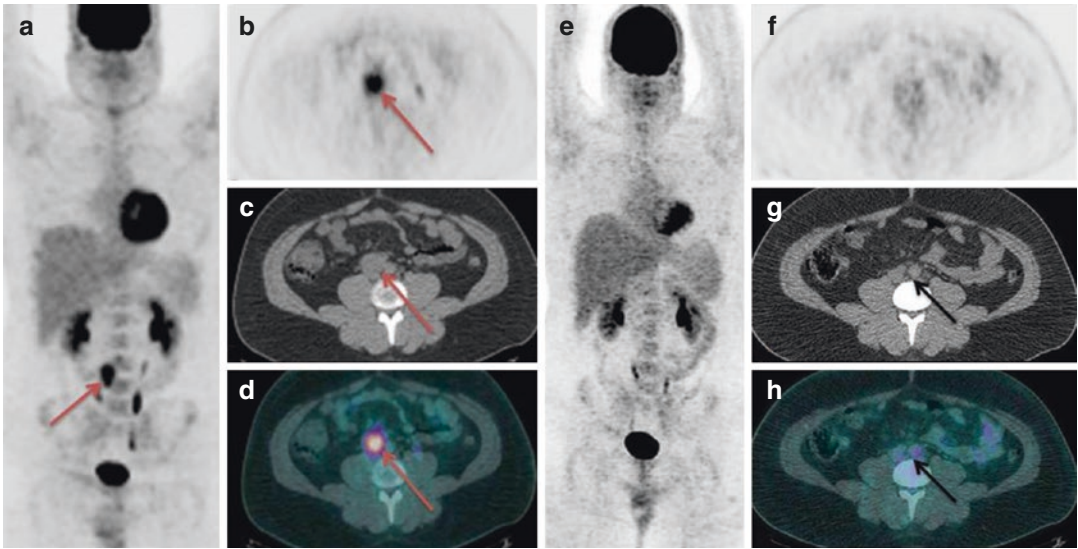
A 23-year-old patient previously submitted to excision of seminoma of the right testicle was examined by PET/CT, showing pathologic tracer uptake in a 2.8-cm-wide abdominal, retrocaval lymphadenopathy (red arrow), evident in MIP (a) and axial PET (b), CT (c), and PET/CT (d) views.
